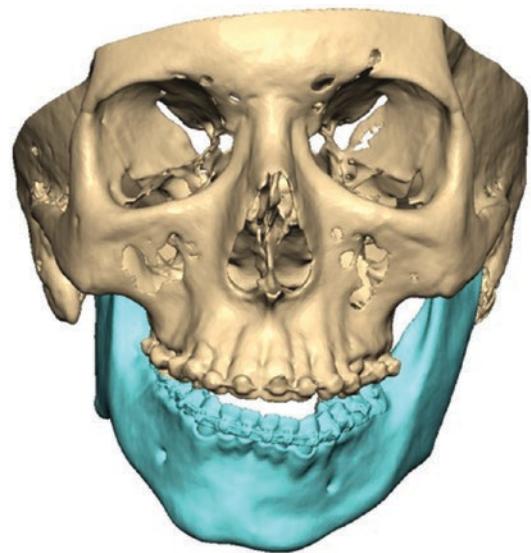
3D rendering obtained from preoperative CBCT
